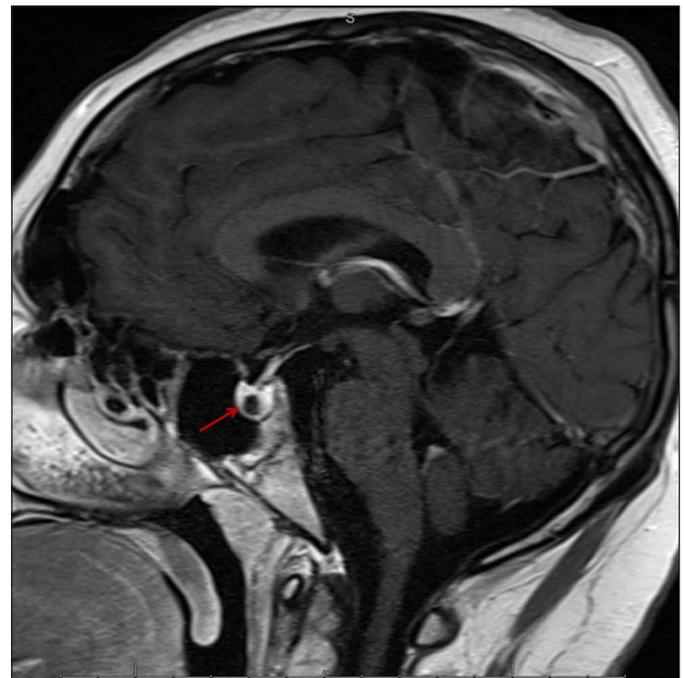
Brain MRI T1/FLAIR with contrast revealed a 5 x 9 x 6 mm hypoenhancing lesion (arrow) in the central aspect of the sella, likely representative of a microadenoma.
